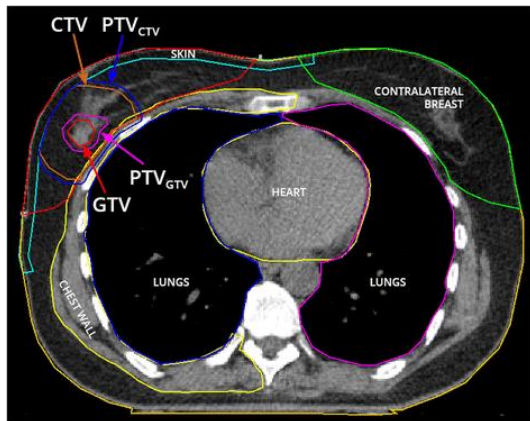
CT of a left breast cancer patient with the OAR (heart), the PTV, and the CTV contoured. Retrieved from [26].
